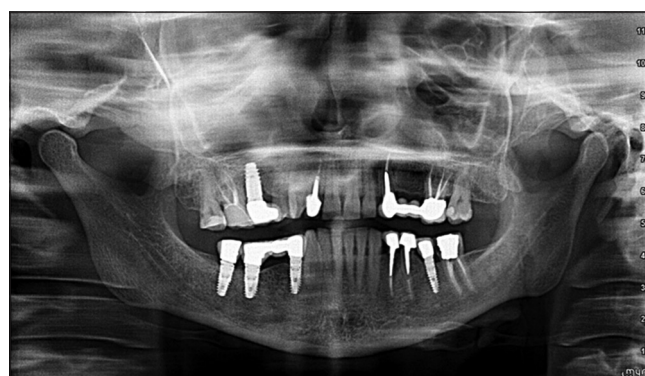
Panoramic radiograph with 12-month follow-up
